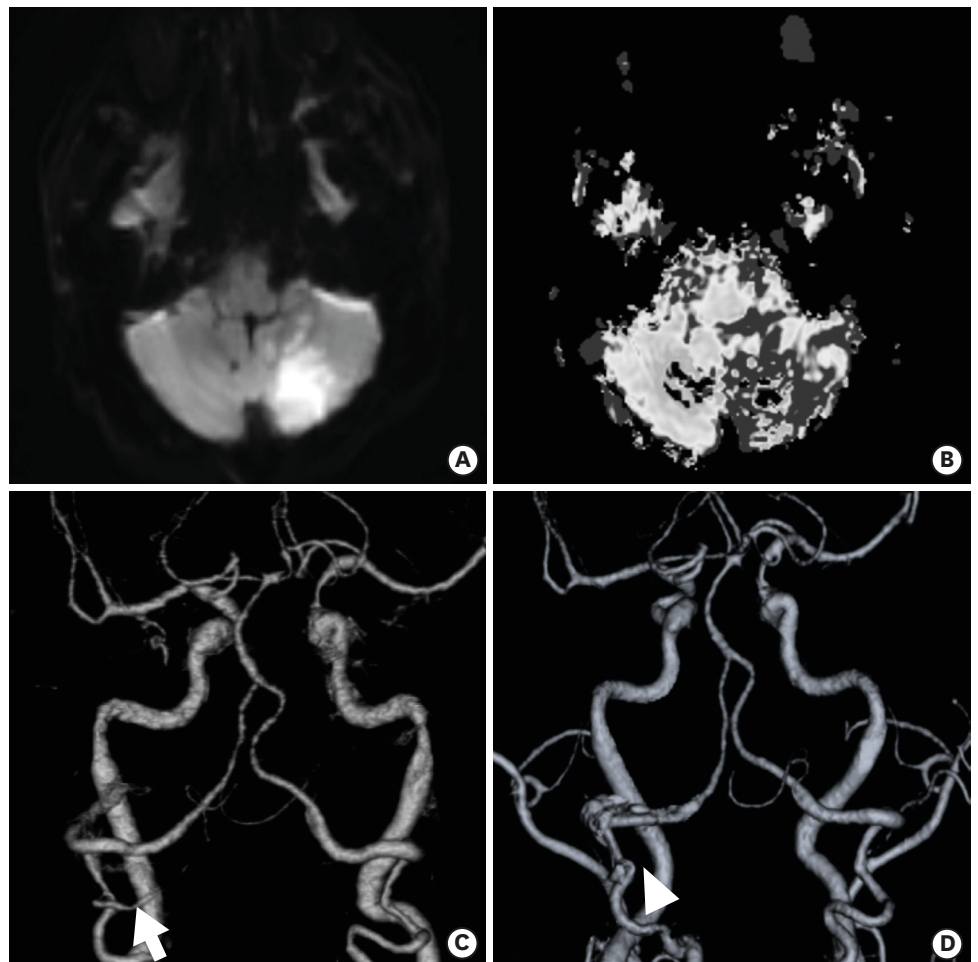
Postoperative brain magnetic resonance images and computed tomography angiography images taken on postoperative day 4. (A) Diffusion-weighted image, (B) Mean transit time image showing acute infarction at the left cerebellum, and (C, D) Comparison with preoperative image (arrow). The left posterior inferior cerebellar artery is not shown (arrowhead).
